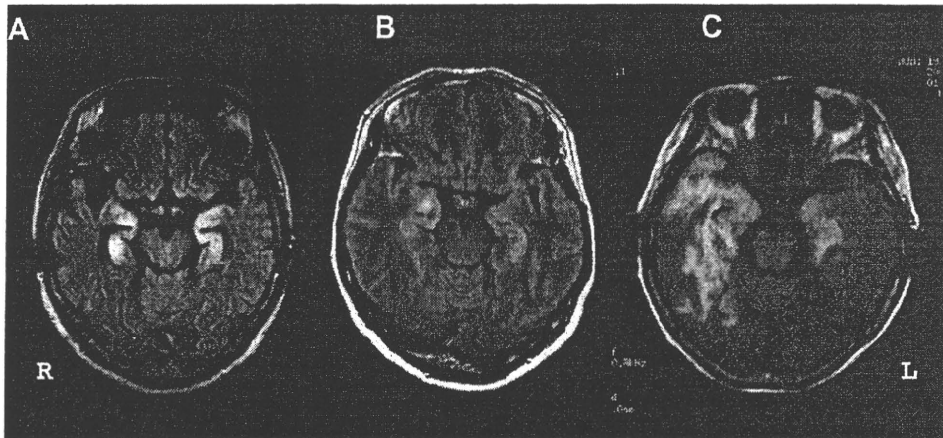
FLAIR MRI of Patient 2 (A), Patient 6 (B), and Patient 9 (C) demonstrated high signal intensity lesions in the bilateral temporal lobes.
